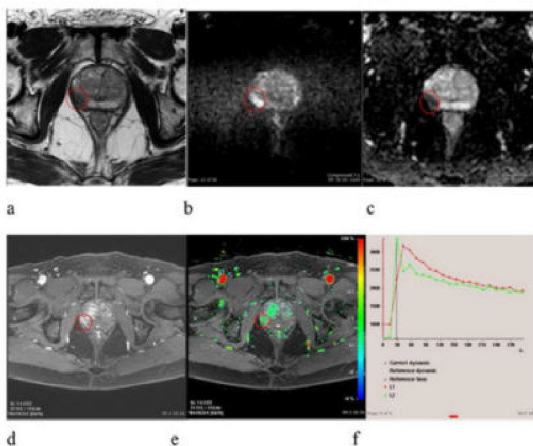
Example of prostate MRI evaluation of an Axial T2WI with a 1.3 cm circumscribed lesion located in the right posterolateral aspect of PZ at midglnd level (marked with a circle); b, c corresponding apparent diffusion coefficient (ADC) map showing
